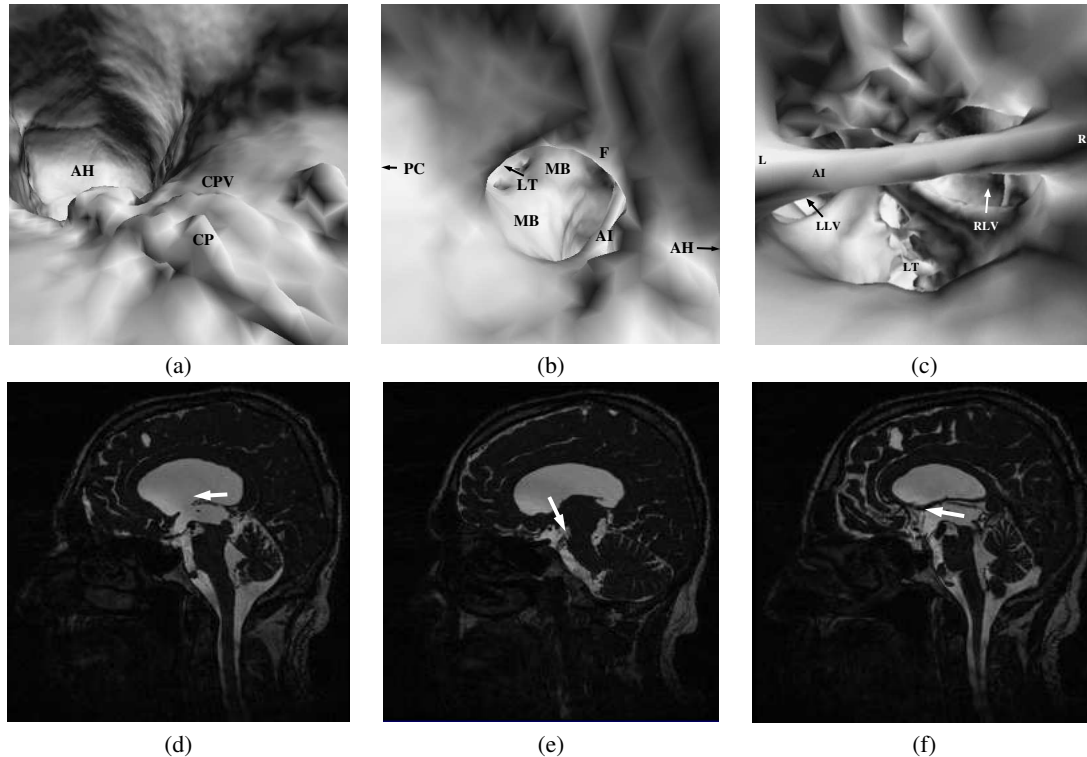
Virtual Ventriculostomy; upper row – endoscopic view, lower row – MRI/3D CISS orientation slice. (a/d) Left lateral ventricle, approach from posterior horn via pars centralis (PC) to anterior horn (AH); (b/e) foramen of Monro, approach via right lateral ventricle; (c/f) foramen of Monro, approach from third ventricle; CP = choroid plexus, CPV = choroid plexus vein, F = fornix, AI = adhesio interthalamica, MB = mamillary bodies, LT = lamina terminalis, LLV = entrance to left lateral ventricle, RLV = entrance to right lateral ventricle¹⁵.
